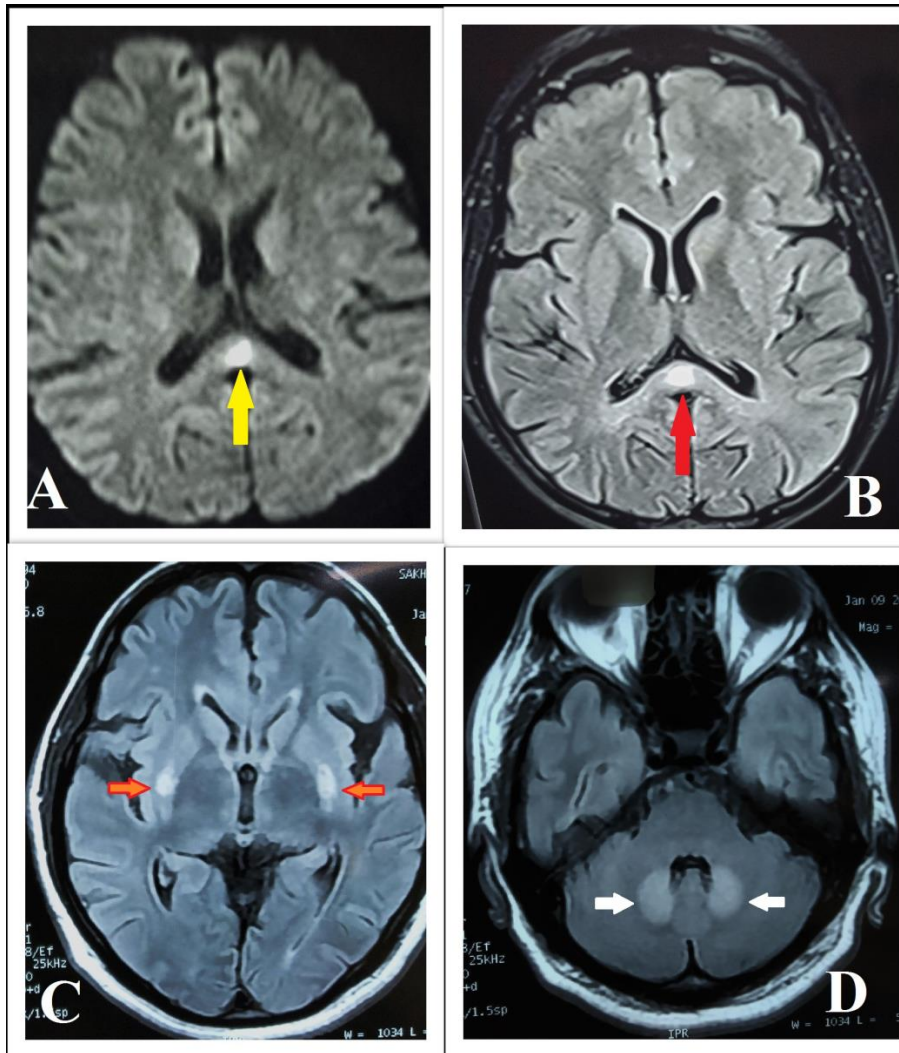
Splenium of corpus callosum shows evidence of diffusion restriction (yellow arrow) as well as hyperintensity (red arrow) on fluid attenuation inversion recovery (FLAIR) scans (Panel A, B); symmetrical areas of hyperintensity involving bilateral lentiform nucleus (orange arrow) and dentate nucleus of cerebellum (white arrow) (Panel C, D)
